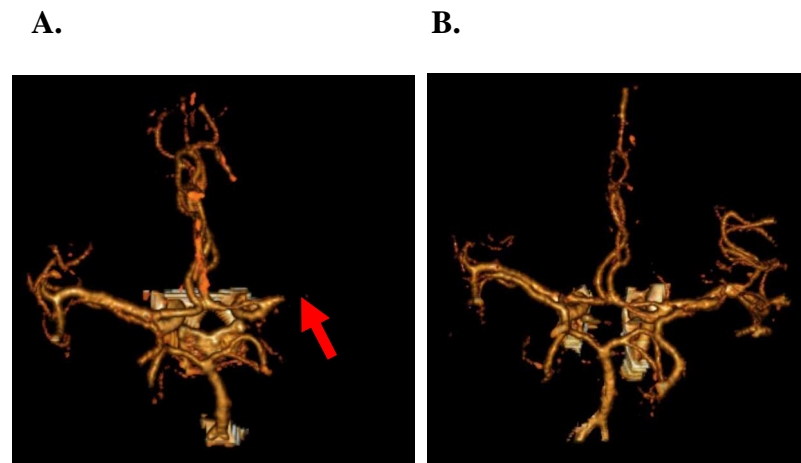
3D CT image of the Circle of Willis of an acute stroke patient with an occluded middle cerebral artery identified by the missing vessel (red arrow) (A) and following thrombolysis (B), where flow is restored to previously ischaemic regions (Images provided by Professor K Muir, Southern General Hospital)
